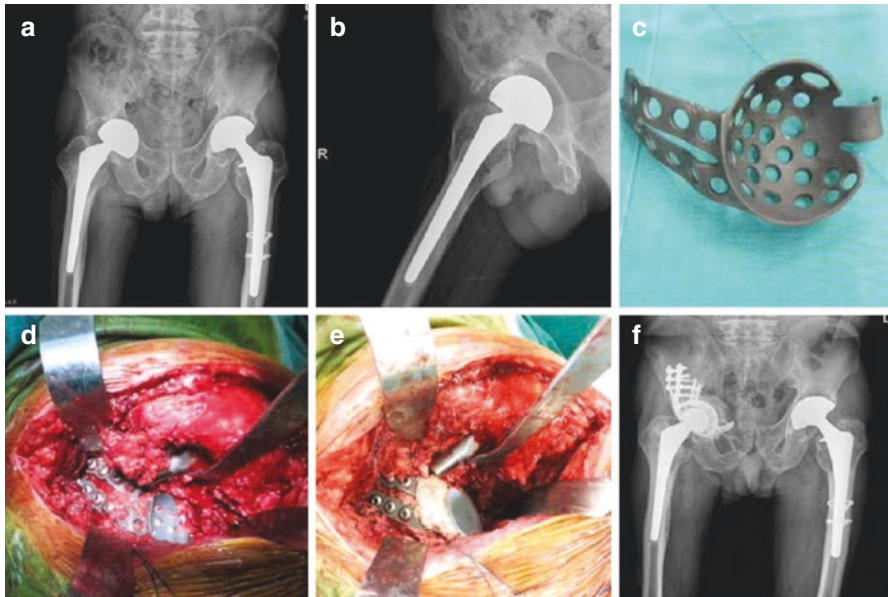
A 75-year-old man had a right bipolar hemiarthroplasty 20 years previously. Preoperative radiography showed a Paprosky type IIC defect of the acetabulum with segmental medial wall defect and ischial osteolysis (a and b). An anti-protrusion cage (Stryker GAP-2) was prepared because of huge medial wall defect 6 × 7 cm (c). Intraoperative pictures showing the cage and allografts reconstruction of the acetabulum (d). And the polyethylene insert was cemented in the optimum position (e). Postoperative radiographs showed a well-fixed cage placed in the optimum position with additional screws fixation from cage to ilium (f) (these pictures were agreed by the patient for publication)
